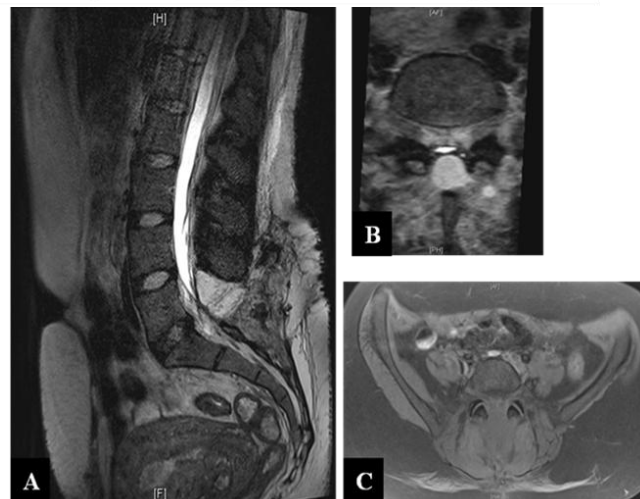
Postoperative Lumbar spine MRI
